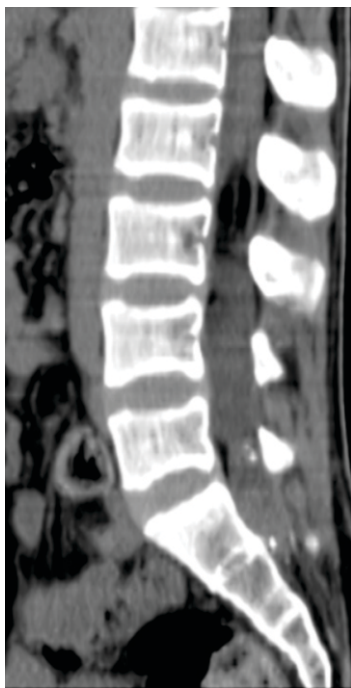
Mid Sagittal Reconstructed CT Image shows the Hypodense (100 to -110 HU) Fat in the Upper One Third, Cystic Component Appearing Isodense (10 to 15 HU) in the Middle One Third And Hyperdense (40 to 50 HU) in the Lower One Third
